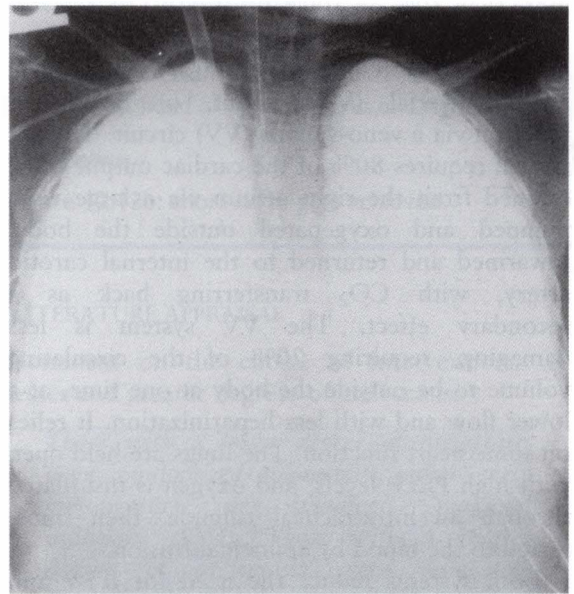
Radiograph of liquid ventilation.
